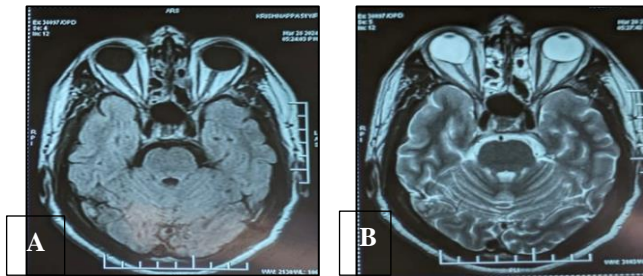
Axial T1WI (A) and T2WI (B) of MRI showing posterior conical shape of the right globe.
